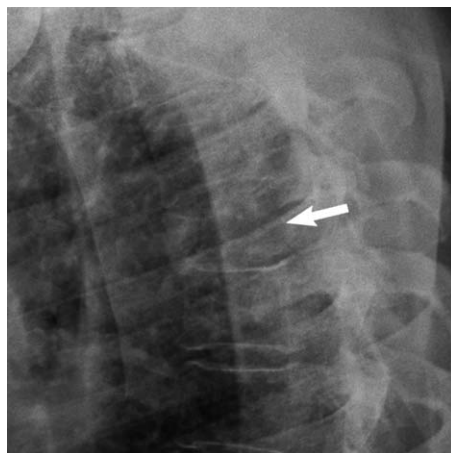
Lateral plain radiograph (same patient as in Fig. 1) demonstrates lytic change and height loss of the T5 vertebral body, with absence of the posterior cortical line (*arrow*).
